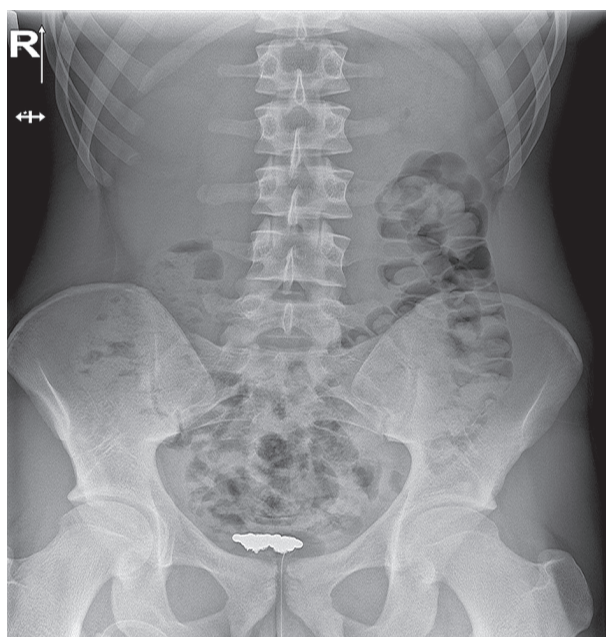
X-ray numerous spherical shading foreign bodies in bladder (Case 1)
